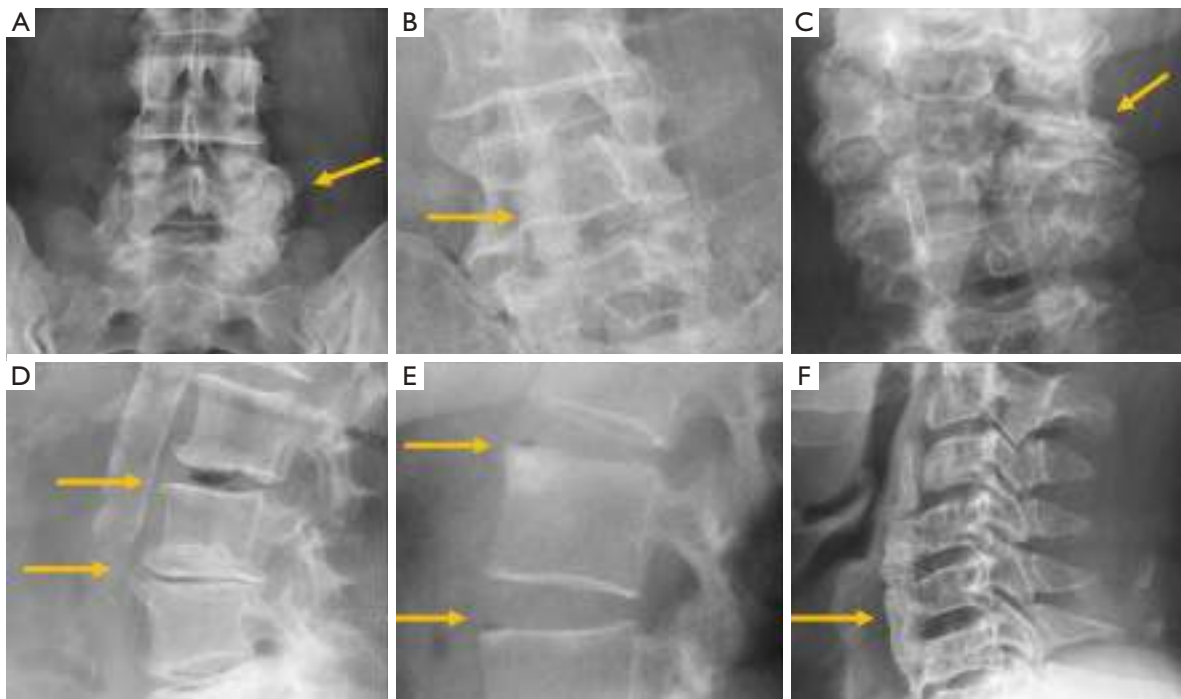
Facet osteoarthritis. AP (A) and oblique (B) lumbar radiographs. (C) Facets osteoarthritis at the cervical spine; (D) vertebral osteochondrosis with marginal osteophytes and central vacuum phenomenon; (E) spondylosis deformans with marginal sclerosis and peripheral vacuum phenomenon; (F) diffuse idiopathic skeletal hyperostosis. Arrows point the main abnormality in each case.
